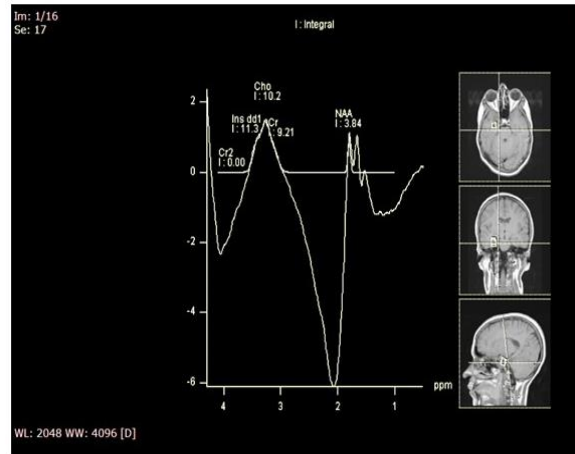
Examples of the MRI results
